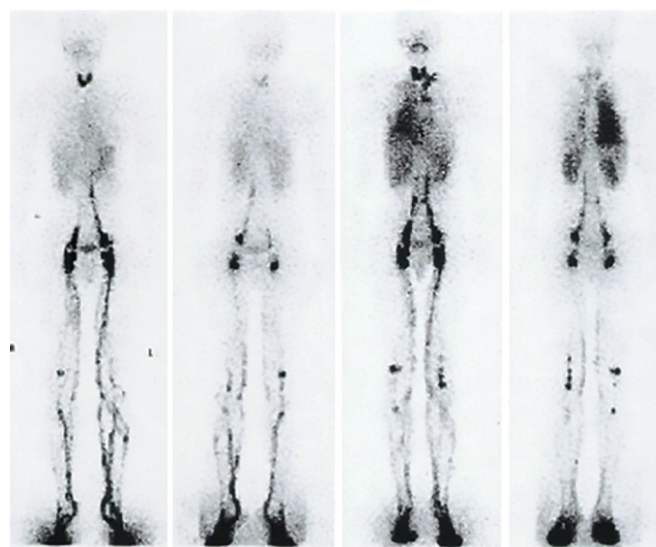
Lymphoscintigraphic image (2 hours post injection) showing significant diffuse uptake of tracer in right thoracic region and abnormal increased uptake in left supraclavicular region and in a linear irregular pattern in the left side of chest
